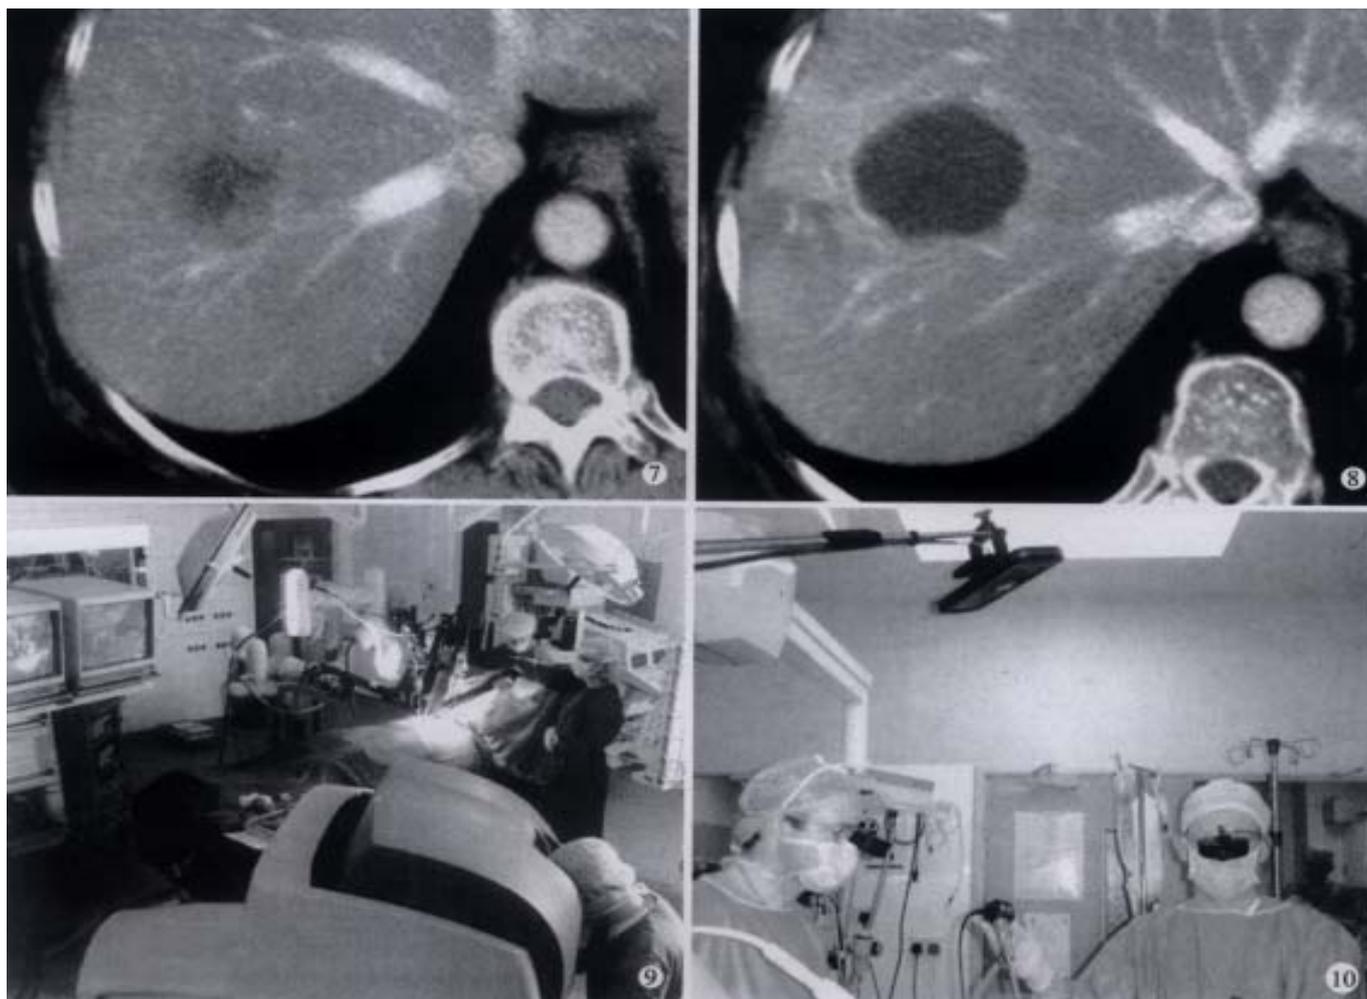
Radiofrequency ablation: CT scan demonstrates A 3.5 cm solitary colorectal metastasis in segment 8 of the right lobe of the liver.
